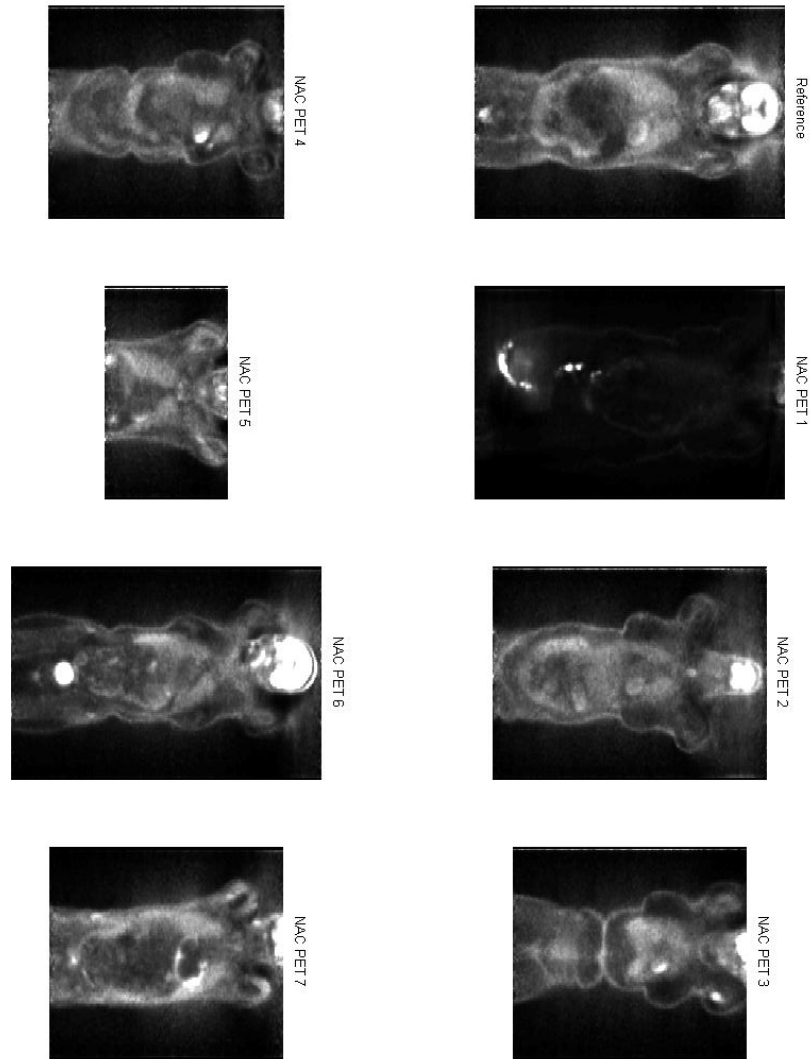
Eight frontal slices of non-attenuation corrected (NAC) PET images of PET/CT volumes acquired by hybrid scanners visualized using the same window/leveling function as in Fig.3.5. This figure visualizes the normalized version.
